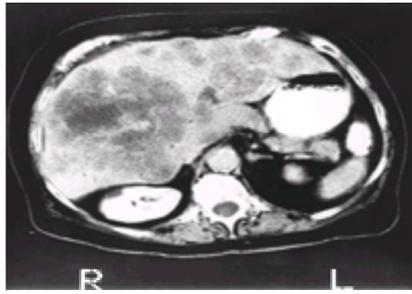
Computed tomography scan of the abdomen of a 72-year-old man with metastatic colon cancer and persistent, right, upper-quadrant abdominal pain. The scan demonstrates extensive liver metastases. L, left; R, right.
